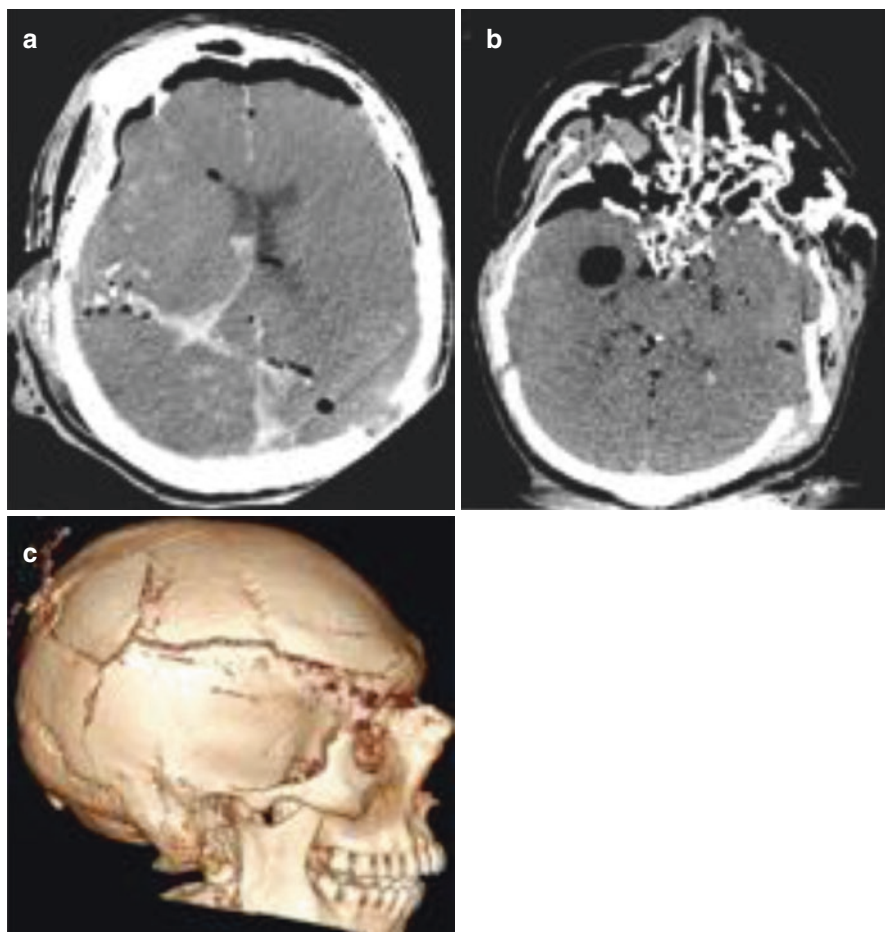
Perforating intracranial injury. (a) Axial CT of a perforating GSW with transventricular tract. (b) Example of retained cavity following GSW. (c) Fractures to the calvarium resulting from cavitation
